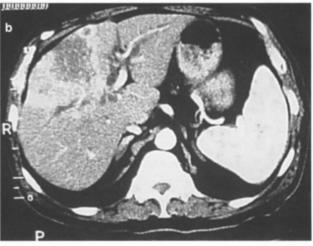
Computed tomography. a) Arterial phase b) portal phase. Peripheral cholangiocarcinoma
